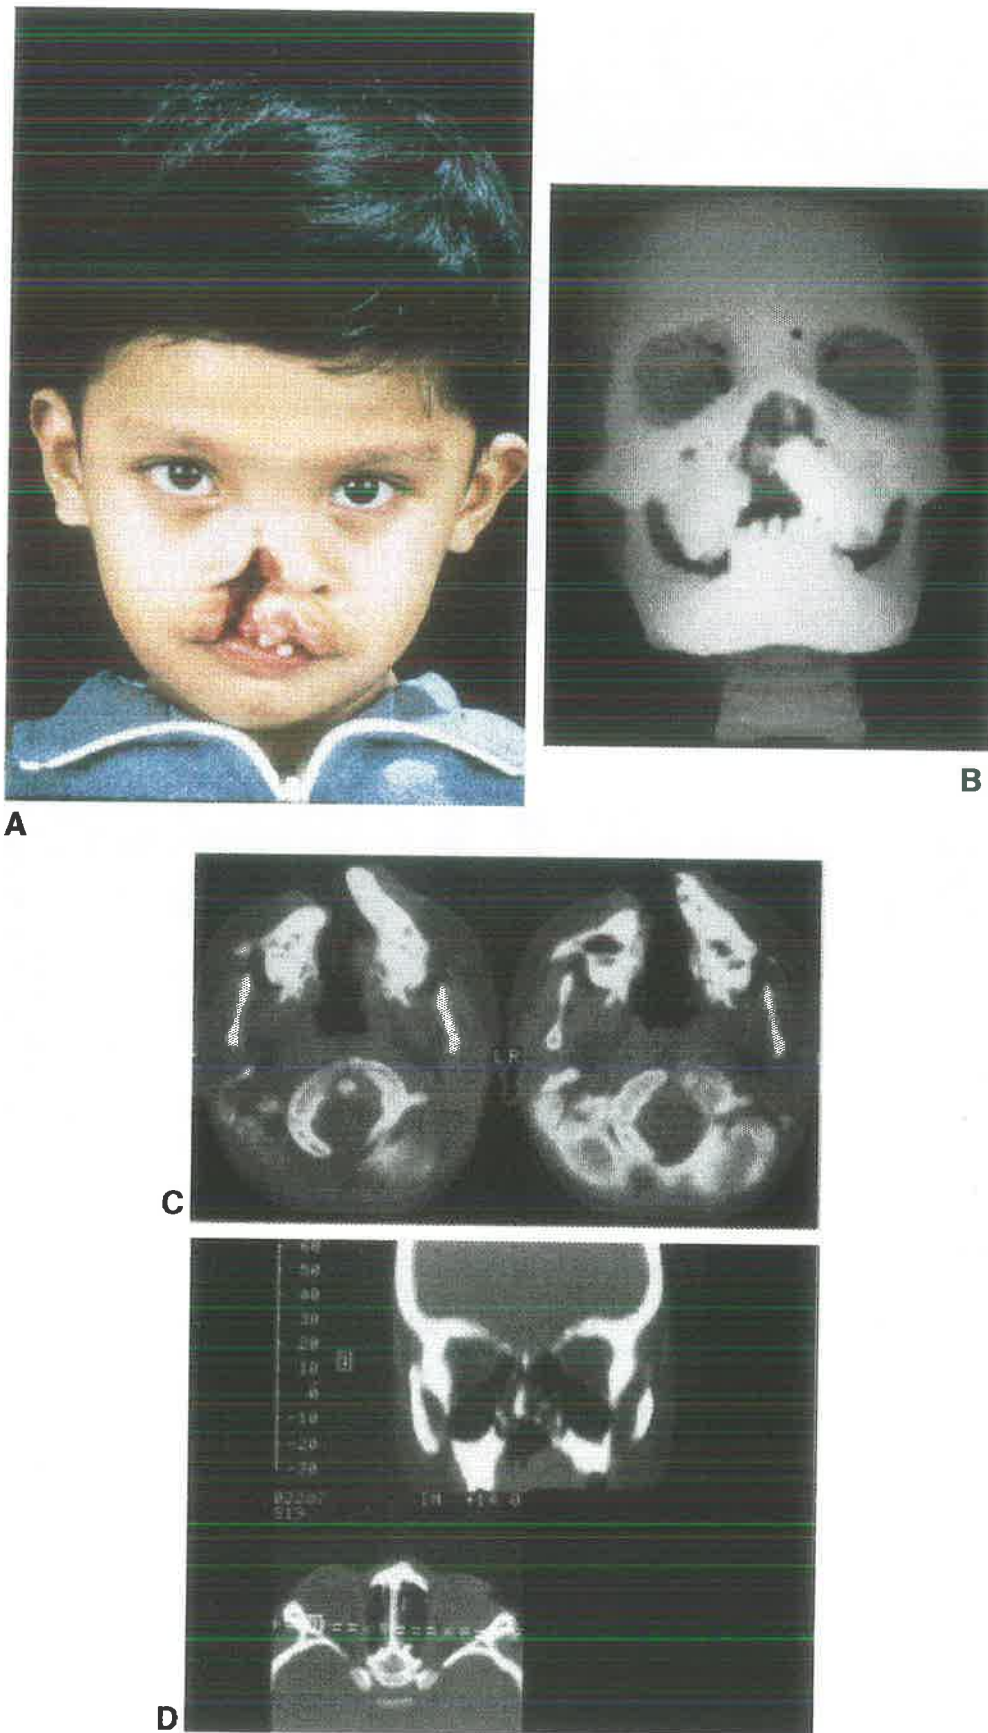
A. Four-year-old Malaysian boy with an unrepaired right-sided cleft of the Tessier Number 2 type. B. Cleft marginal hypoplasia produces a characteristic keel-shaped alveolus and hypoplastic maxilla. C. Axial two-dimensional CT scan shows the alveolar cleft and inferior displacement of the cleft side maxilla. D. Coronal two-dimensional CT reformat through the posterior orbits demonstrates the asymmetry extending from below in the maxilla, through the ethmoids, to the anterior cranial fossa.
